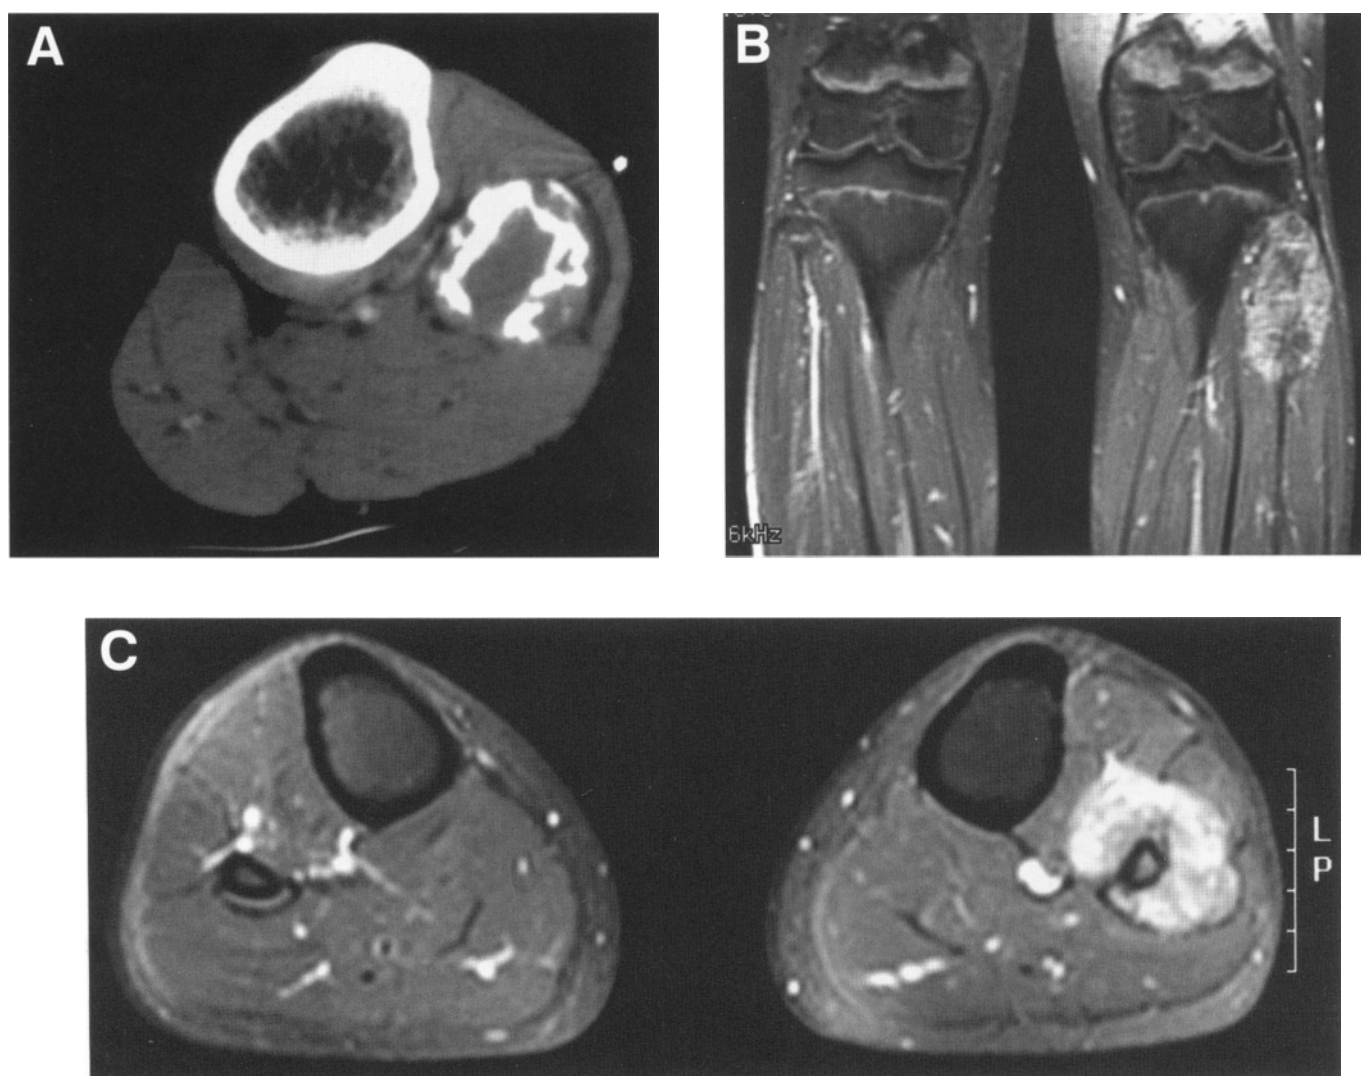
(A) Computed axial tomography of the proximal fibula showing an intermediate-grade fibrosarcoma with cortical breakthrough and extraosseous extension. (B) and (C) are coronal and axial magnetic resonance images of the proximal fibula, respectively, showing a high-grade osteosarcoma with cortical breakthrough and extension to the anterior and lateral compartments of the leg.
